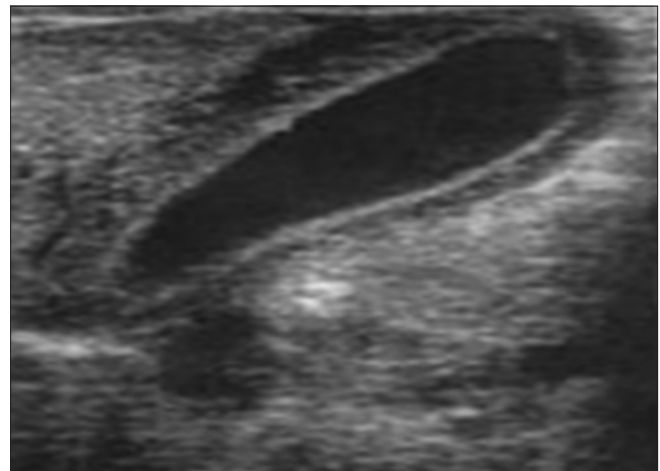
A 47 years female patient with dengue fever, ultrasound shows thickened and edematous gall bladder wall (arrow)
